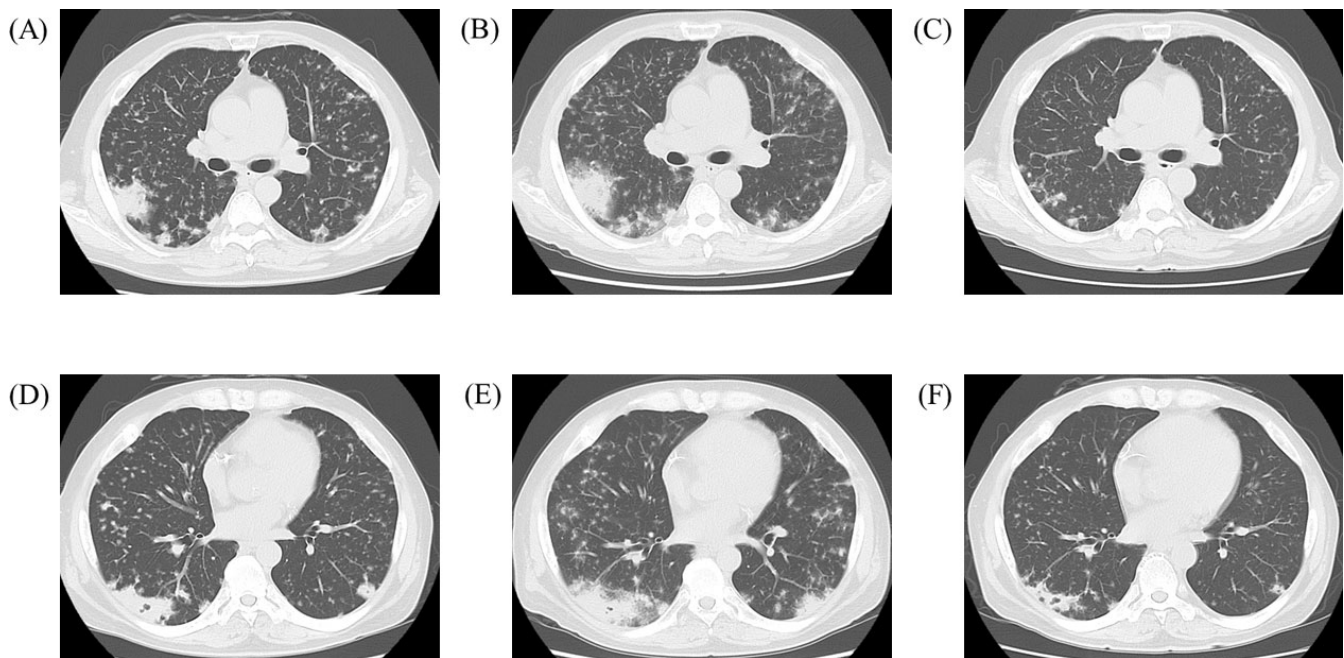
Pre-treatment chest CT images showing the primary lesion accompanied by ground glass opacities at right S²a (A) and multiple lung metastases in all lung lobes (A, D). Chest CT images obtained on day 14 of the first cycle showing disease progression in the primary lesion (B) and multiple lung metastases (B, E). Chest CT images obtained on day 36 after the treatment initiation showing reduction in primary lesion size and multiple lung metastases (C, F). CT, computed tomography
